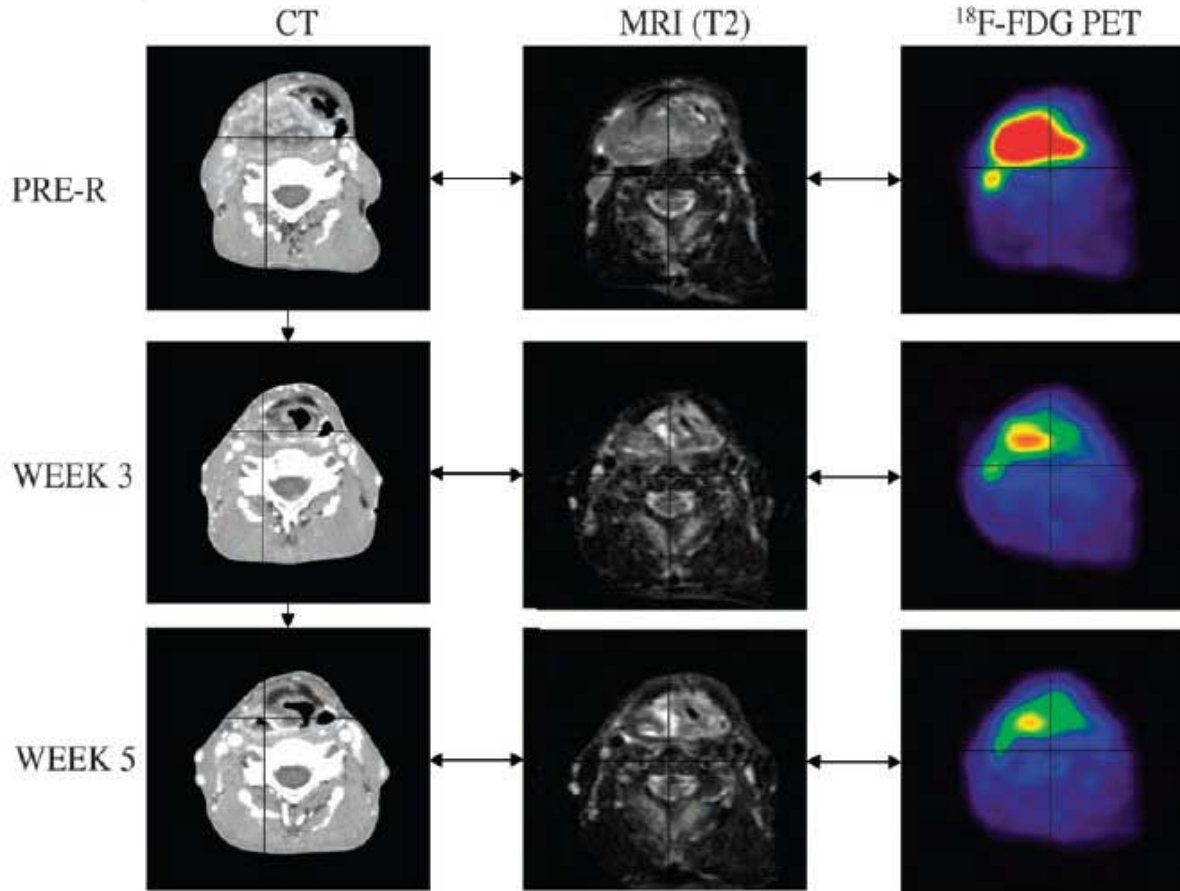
Patient with T4 N3 M0 squamous cell carcinoma of right piriform sinus. CT, MRI (T2-weighted fat suppression), and ¹⁸F-FDG PET were performed before treatment (PRE-R) and during wk 3 (26 Gy) and wk 5 (46 Gy) of treatment with chemoradiotherapy. Three sets of images were coregistered by use of semiautomatic tool based on isocontouring. Substantial reduction in tumor volume and metabolic activity can be observed throughout treatment.
